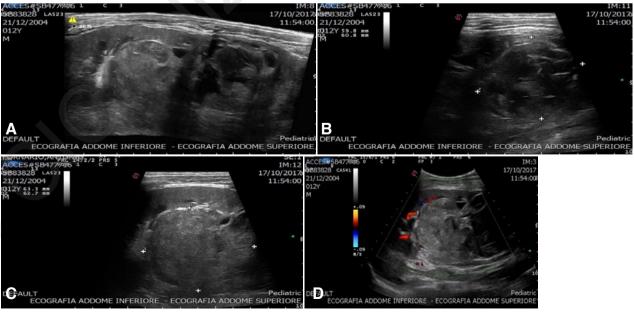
(A-D). Ultrasound images of the abdomen (October 2017): voluminous mass of the left kidney with inhomogeneous and mixed echostructure (A-C), without vascularization (D).
